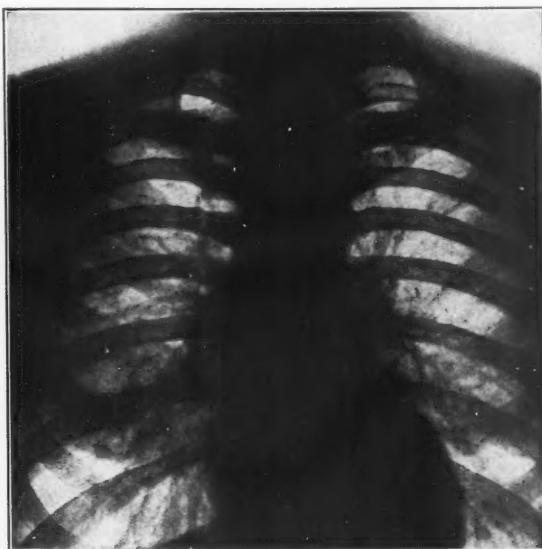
PATIENT H.—: PLAIN FILM SHOWING AREA OF IRREGULARLY DECREASED TRANSLUCENCE IN RIGHT MID ZONE.
